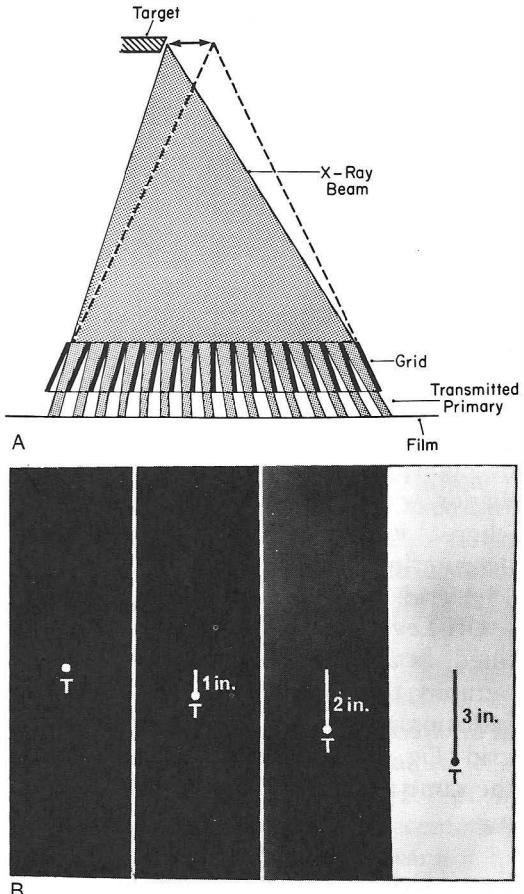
Cutoff from lateral decentering, (A) and series of radiographs resulting from increasing amounts of lateral decentering (B)
